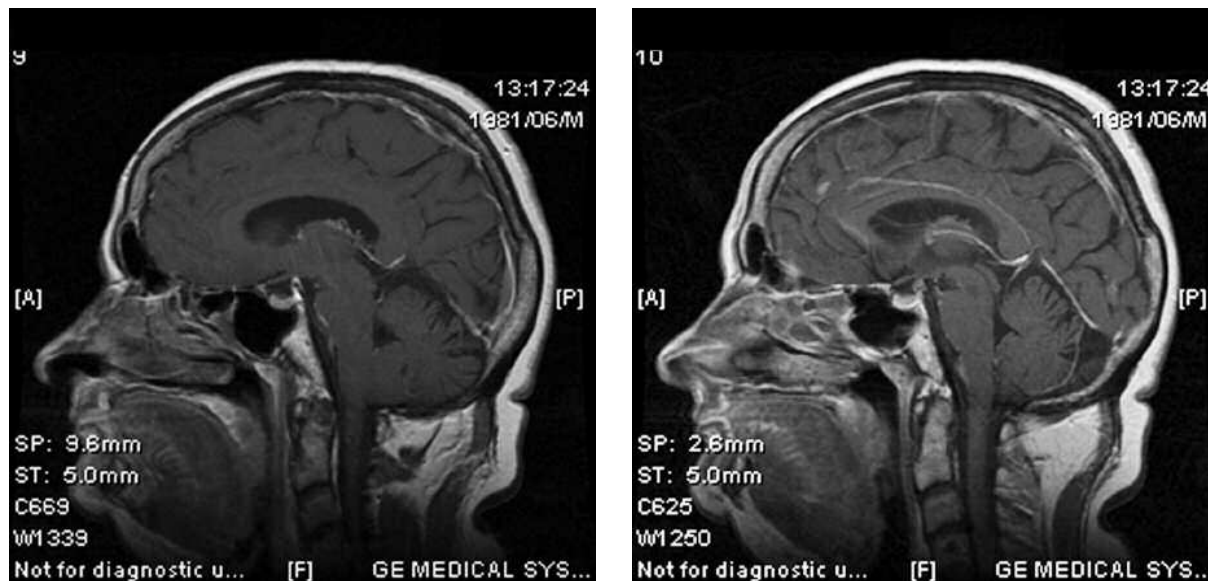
Current control T1-weighted MRI sagittal images with contrast enhancement
